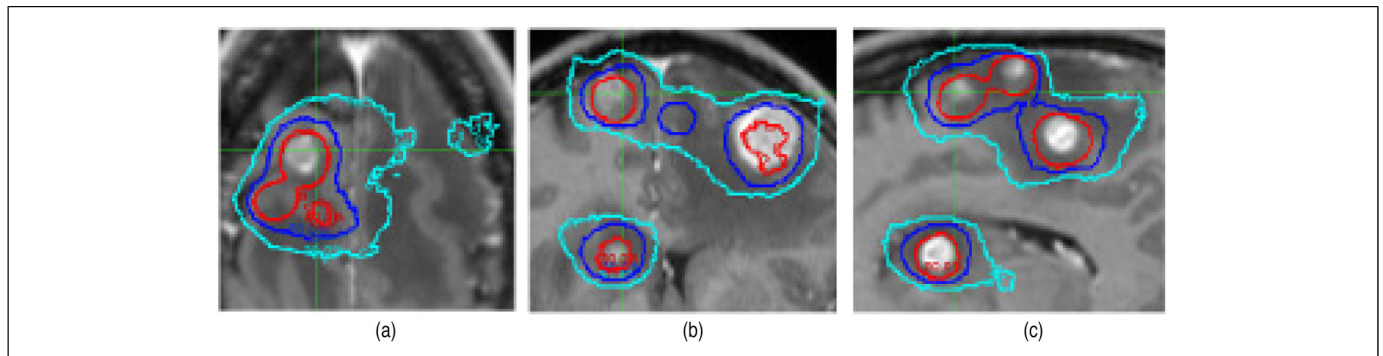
Comparison of Monte Carlo dose contours based on the true CT and sCT (case #1). The axial (a), coronal (b), and sagittal (c) planes are shown. Three iso dose lines are demonstrated: red: 80%, blue: 50%, and cyan: 30%. The thin lines are the results calculated from the true CT and the thick lines are the results calculated from the sCT.
